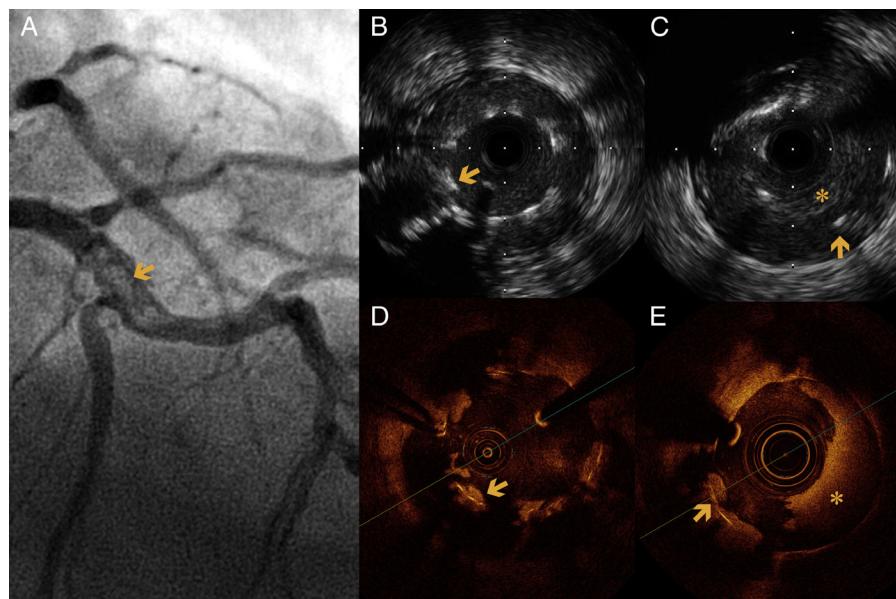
(A) Coronary angiography of the left anterior descending artery (LAD) in right anterior oblique cranial view, showing an extensive intraluminal filling defect, multilobed, compatible with stent thrombosis (arrow). (B and C) Intravascular ultrasound (IVUS) images showing extensive stent strut malapposition (arrow), which appears to be coated with echogenic tissue that could correspond to adherent thrombus. (C) Extensive stent thrombosis (asterisk) and aneurysmal dilatation of the vessel outside the struts (arrow). (D and E) Optical coherence tomography (OCT) images at the same level as the previous IVUS, showing strut malapposition (arrow) with adherent platelet thrombus. (E) Extensive stent thrombosis (asterisk).
